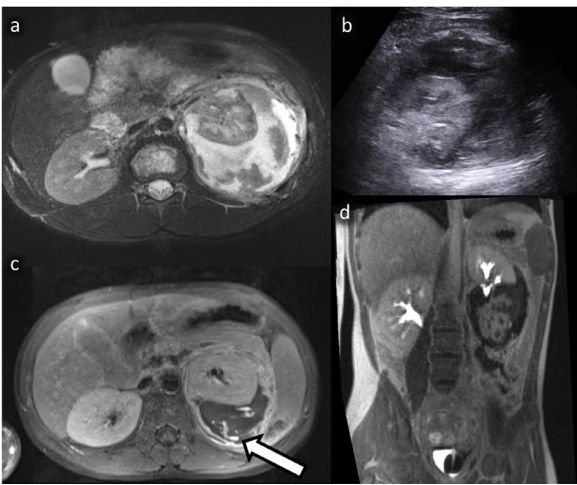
A-D: Urinoma after grade V injury of the left kidney (patient seen in Figure 5). The left lower moiety is devascularized. T2-weighted MRI (A) and ultrasound (B) in axial orientation demonstrate heterogeneous perirenal fluid collections. After administration of intravenous contrast, MRI shows contrast leakages (C) in terms of an urinoma. Note the devascularized caudal renal portion on the left (D). Due to expanding urinoma the patient was treated with ureteral stent placement and percutaneous drainage. In the further course the devascularized part of the left kidney was resected.
